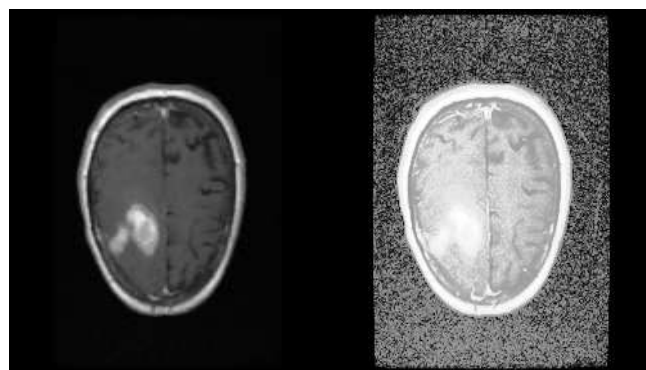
showed the original MRI T1 weight image with gadolinium enhancement (left), increasing the image contrast among the uniform areas using histogram equalization function (right).
